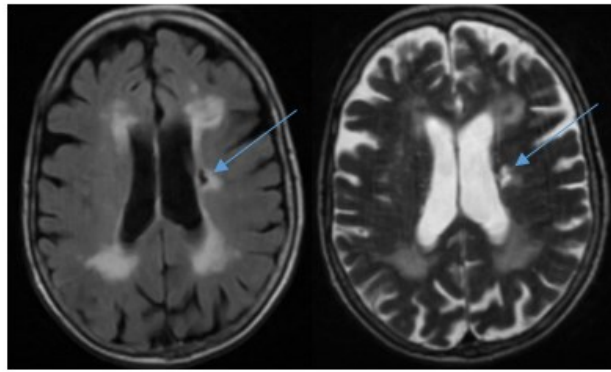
Axial (A) FLAIR and (B) T2-weighted MRI showing a lacune in a participant from the LBC 1936.
